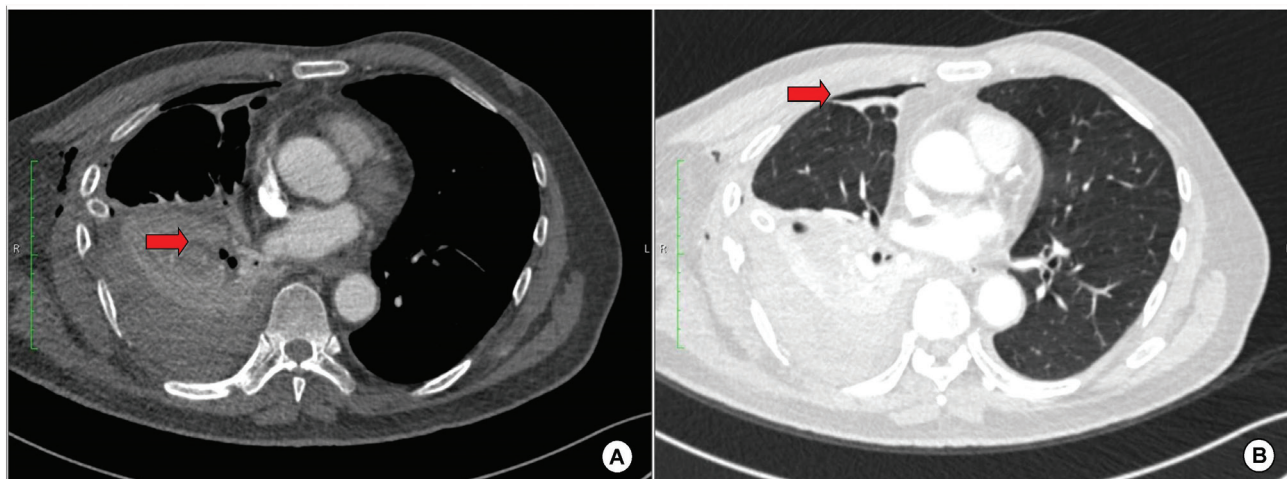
CT thorax. (A) Multiple areas of hypodense lesions (red arrow) in the right lower lobe suggestive of pulmonary laceration. (B) Minimal right pneumothorax (red arrow).
